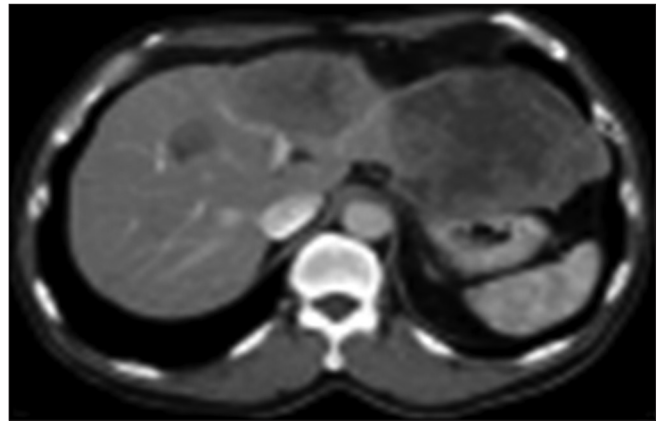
Computed tomography scan showing a large heterogeneously enhancing tumor in the left lobe of the liver
